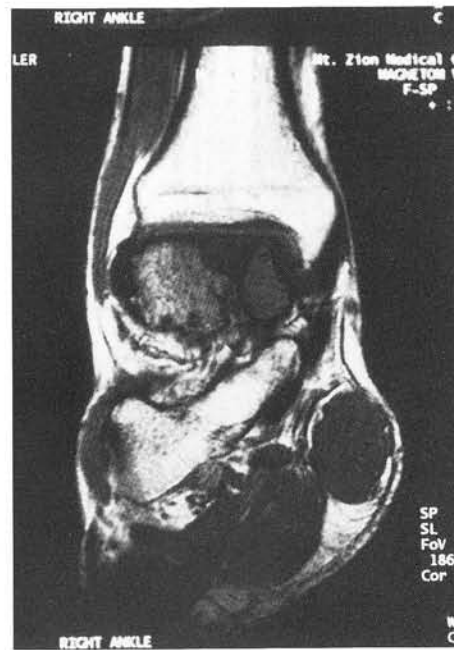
Frontal T-1 MRI image.
